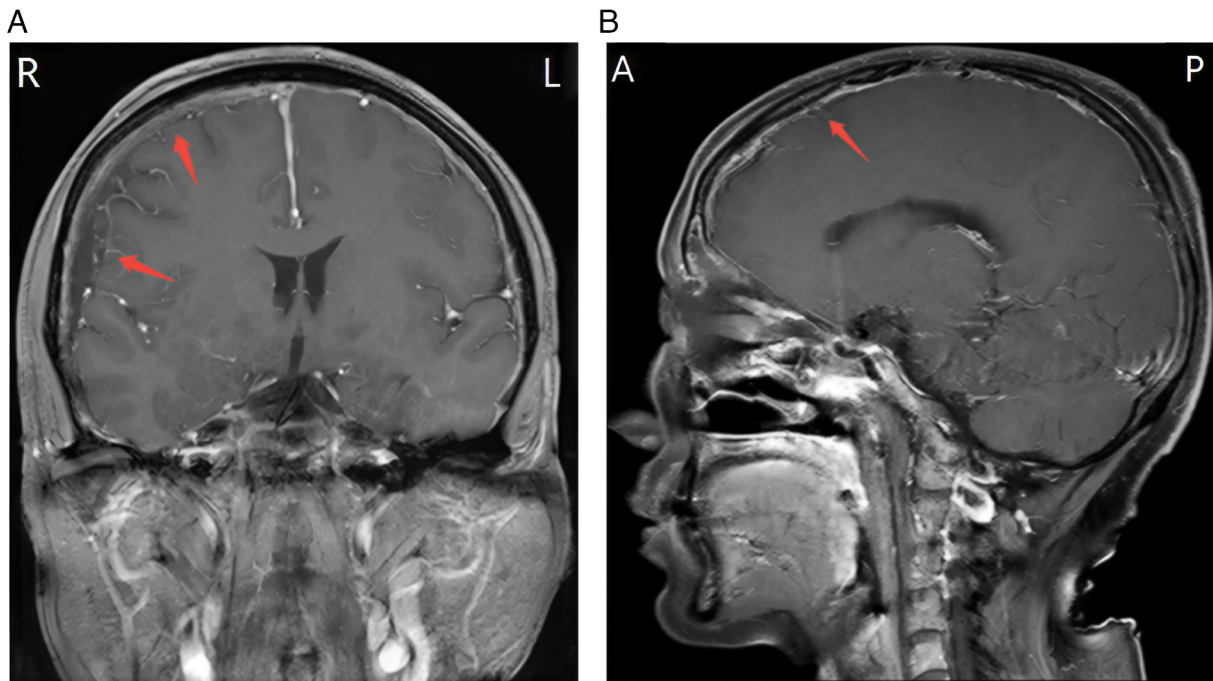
Enhanced brain MRI. (A) Coronal and (B) sagittal planes with diffuse meningeal thickening and hyperintensity. The slight effusion beneath the meninges on the right forehead indicated extensive meningeal metastasis.
